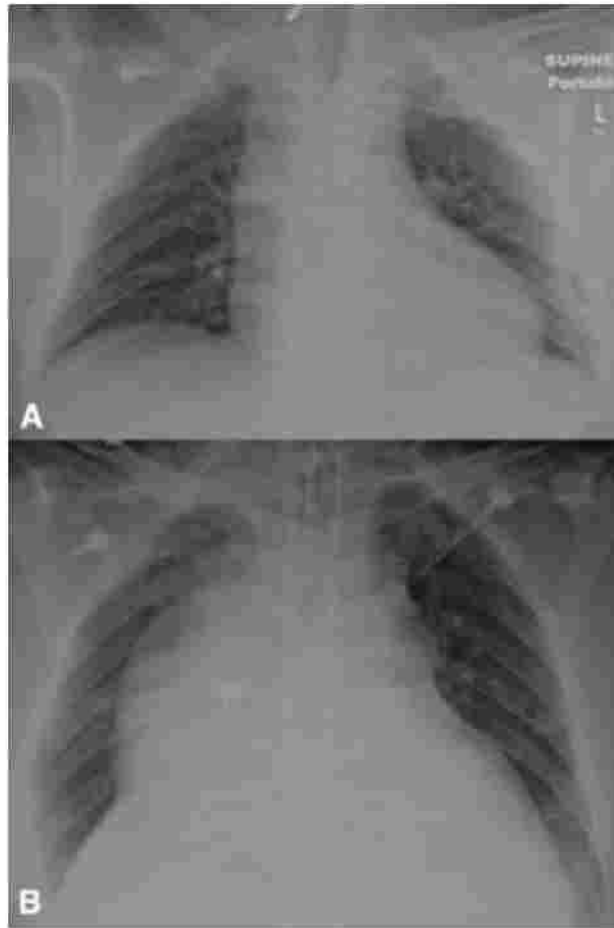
Chest radiographs. A: Initial supine chest radiograph in a trauma patient. B: Repeat chest X-ray study 22 h later demonstrating significant increased density involving the right hemithorax, believed to represent mediastinal blood.
